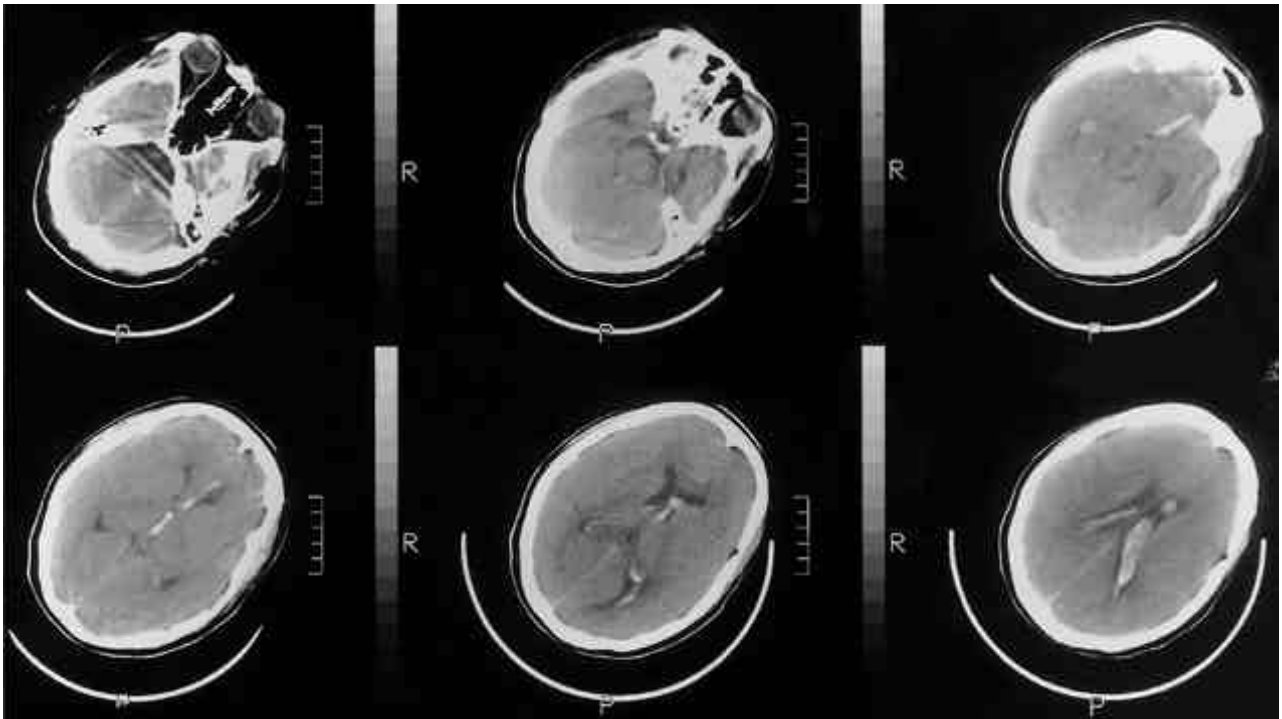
Brain CT on admission shows diffuse intraventricular hemorrhage, a small intracerebral hematoma at the inferomedial part of the left frontal lobe, and moderately enlarged ventricles.
